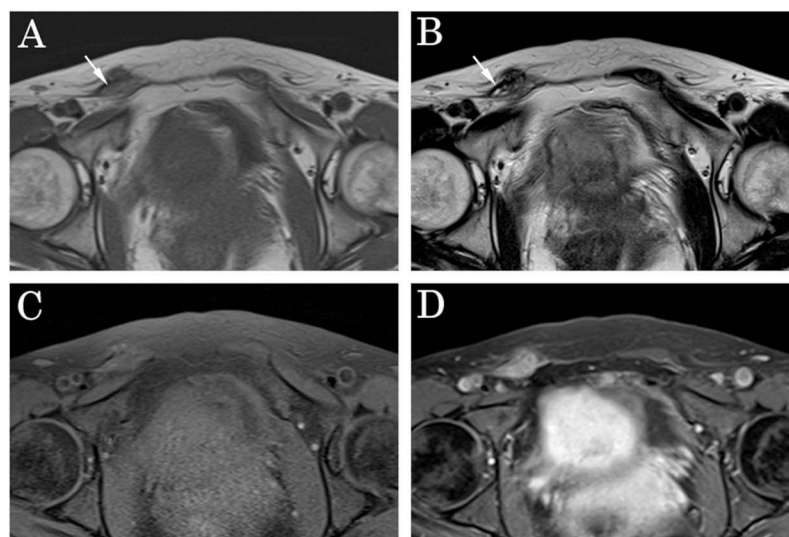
A 51-year-old woman with right inguinal endometriosis (Case 1). The preoperative magnetic resonance imaging showed a 1-cm ill-defined mass over the right pubis. On T1- and T2-weighted images, the tumor was isointense compared with muscle (A and B). On contrast-enhanced T1-weighted imaging, the tumor was enhanced homogeneously (C and D). The lesions contained small foci, showing hyperintensity on T1- and T2-weighted images (arrows). Similar findings were observed in cases 5–8.
